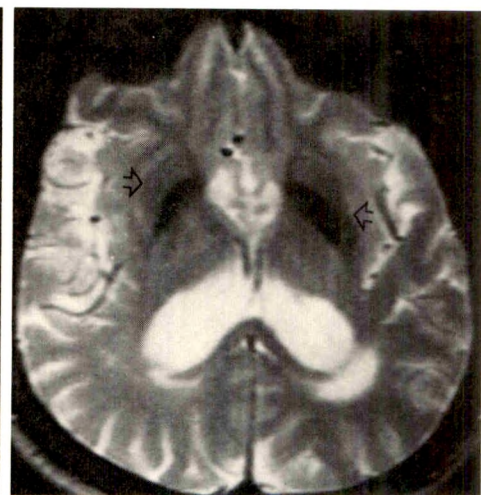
MR image (2500/80) of 76-year-old man with Parkinson disease. Hypointensity is limited to lateral aspect of putamina. (arrowheads), left side greater than right. Both were graded 1.
